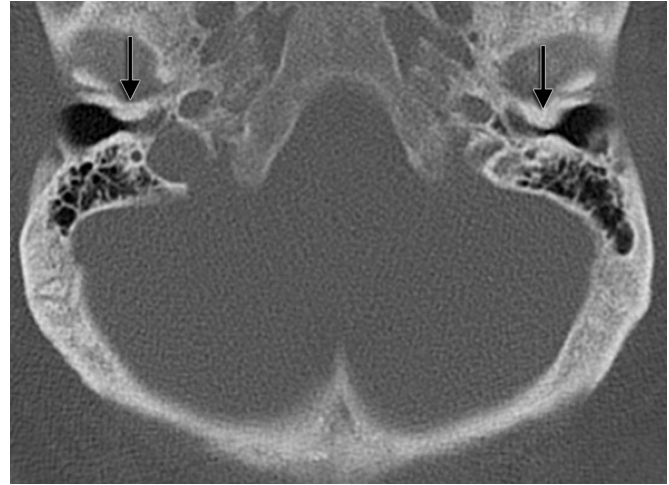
Exostoses. Noncontrast axial CT image demonstrates broad-based osseous excrescences (black arrows) narrowing the medial EACs bilaterally.
